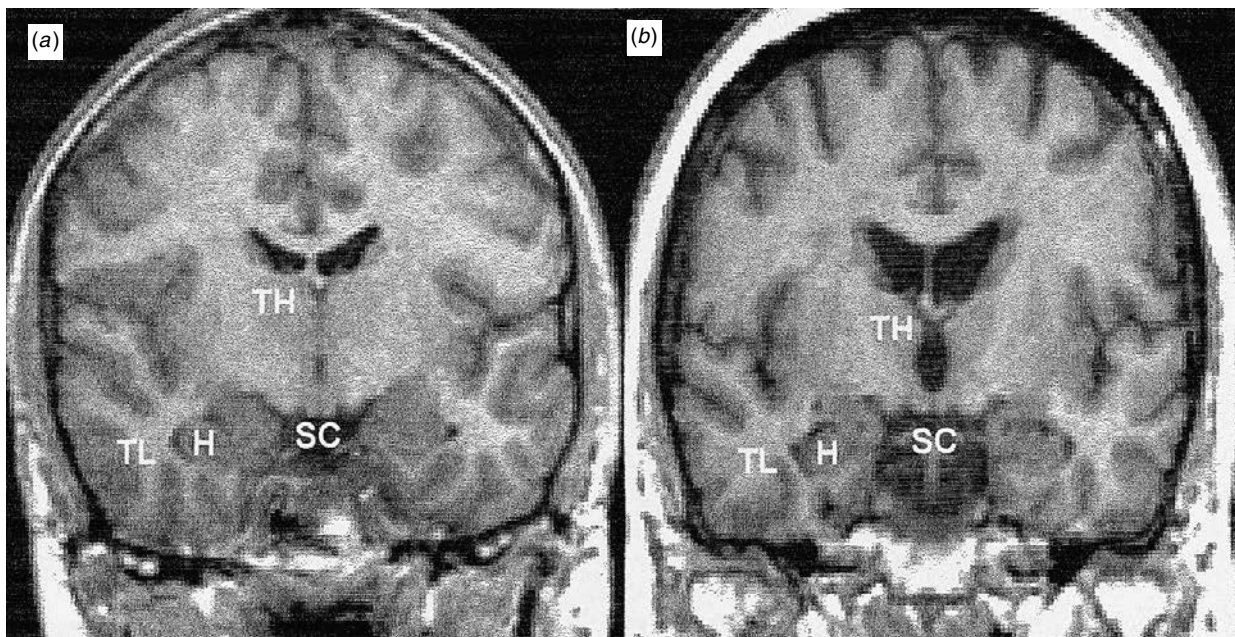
An example of a structural MRI (a) in a healthy young and (b) healthy older individual. H = hippocampus, TH = thalamus, SC = suprasellar cistern
